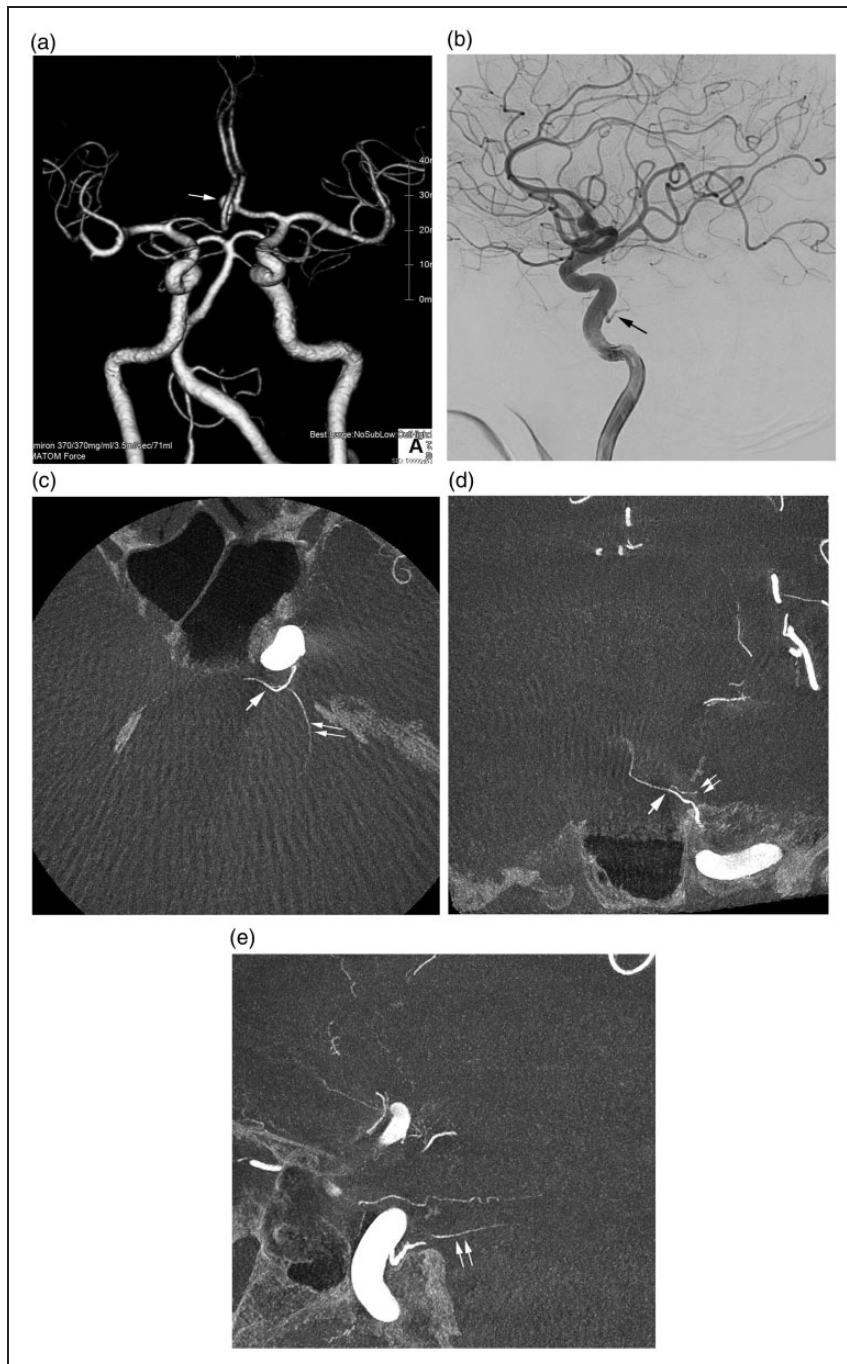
A small trigeminal artery variant exclusively supplying the brainstem in a 73-year-old man with an unruptured anterior communicating aneurysm. (a) CT angiography fails to show left trigeminal artery variant as well as anterior inferior cerebellar arteries bilaterally. Arrow indicates an unruptured anterior communicating aneurysm. (b) Left internal carotid angiogram (lateral view) showing a small artery at the C4 portion. However, its vascular territory is not clear. (c, d and e) The source images of the three-dimensional rotational angiography of the left internal carotid injection clearly show the trigeminal artery variant supplies exclusively the brainstem. Single arrows indicate the bifurcation of the trigeminal artery variant into the midline branch and circumferential branch (double arrows). Blood supply to the mid-pons from the trigeminal artery variant in this patient could be related to the non-visualization (hypoplasia) of bilateral anterior inferior cerebellar arteries.
